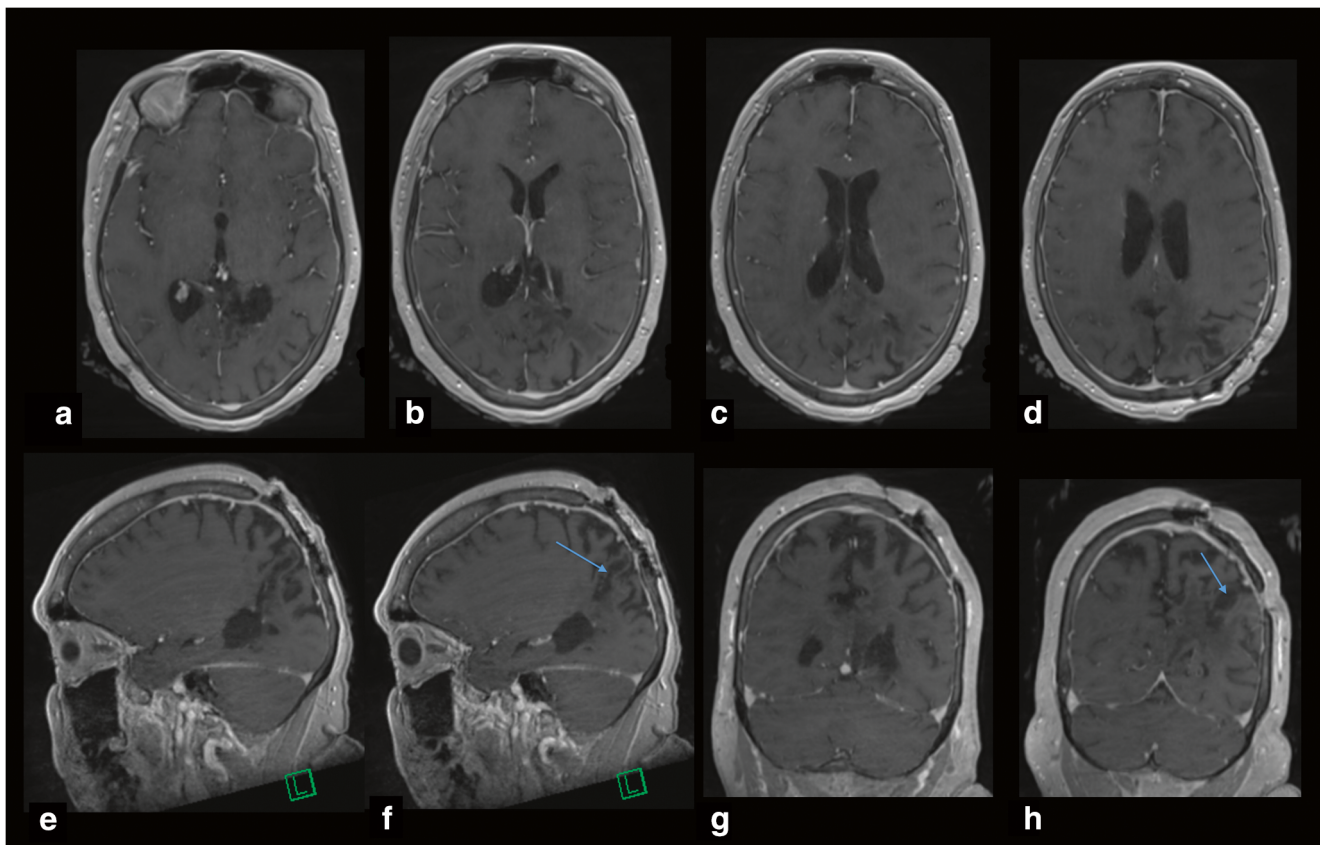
Late postoperative, contrasted axial (a–d), sagittal (e, f), and coronal (g, h) MRI showing the complete removal of the meningioma. The arrows in images f and h indicate the path of the port towards the atrium with minimal surrounding intrinsic parenchymal changes
